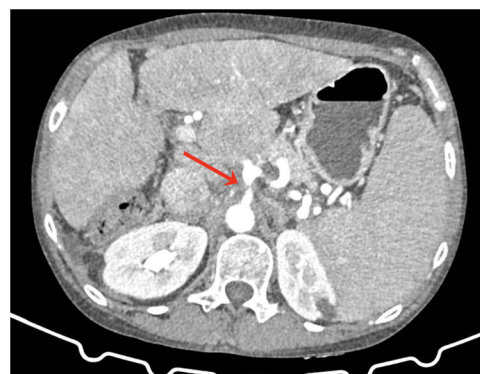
CT (red arrow) of stenosis of the celiac trunk due to MALS.
